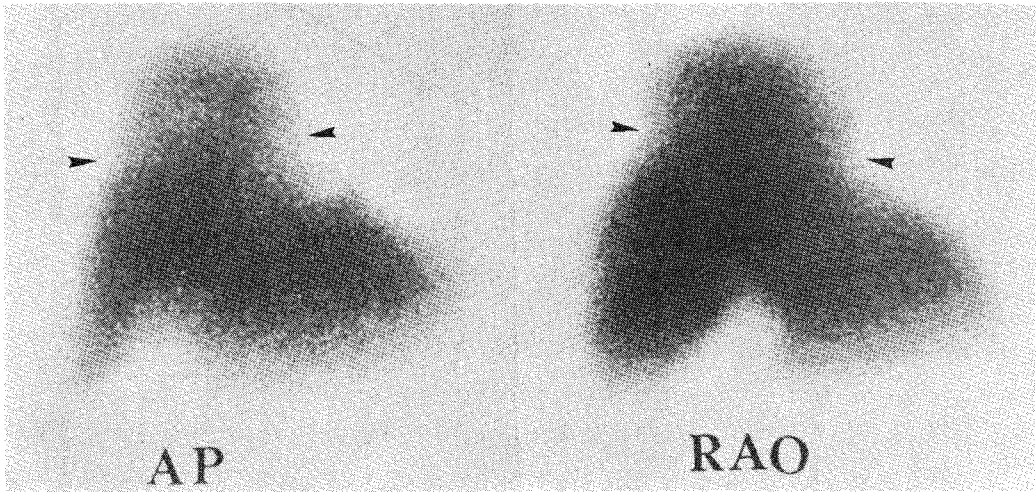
Hepatic scintigram showing abnormal elevation of the right hepatic lobe with a ring of compression (arrow heads). No band-like photon defect was not demonstrated in this case.
